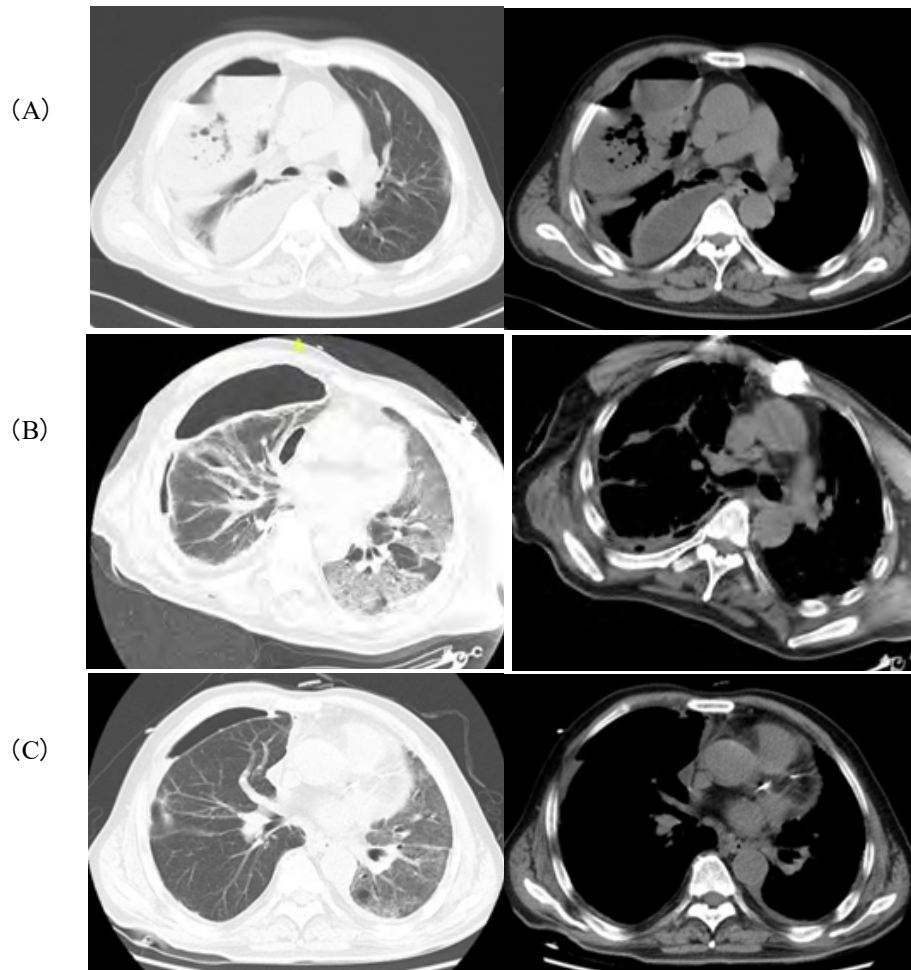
Comparison of chest CT before and after treatment: A: Before treatment (June 19): right pleural enveloping effusion with infection and double lungs inflammation; B: After chest drainage (June 21): right effusion decreased, right lung reopened, left lung progressed compared to before; C: Get better after treatment (August 5): right effusion and pneumonia improved significantly, left lung infection improved compared to before.
